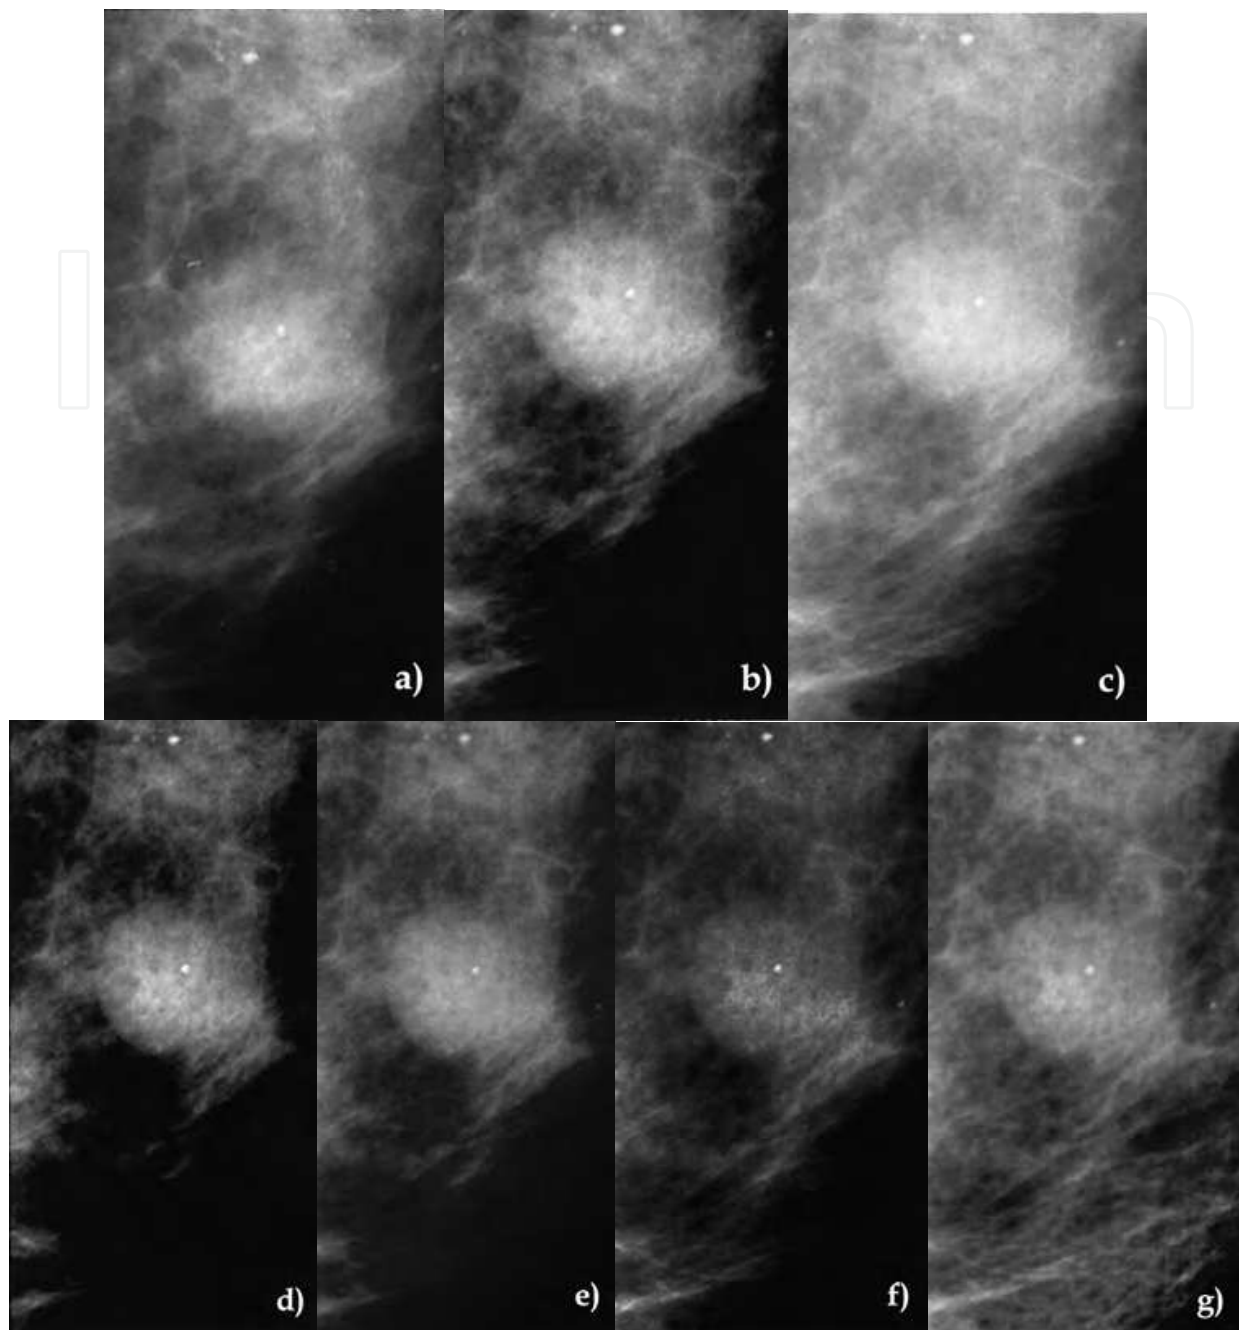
Different post-processing algorithms (a) SFM of a cyst. (b-g) Photographic magnifications of a digital mammogram process with MIW (b), HIW (c), MMIW (d), CLAHE (e), unsharp masking (f), and peripheral equalization (g) (from *RadioGraphics*. Pisano et al. 2005. With permission).
